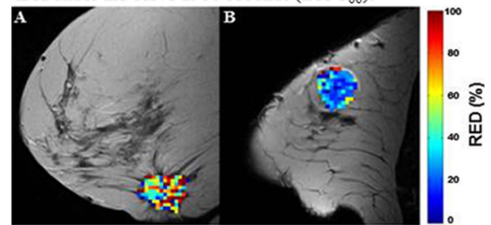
Relative enhanced diffusivity (RED) maps overlaid on T2-weighted images for (A): Invasive ductal carcinoma and (B): Benign phyllodes tumor.
